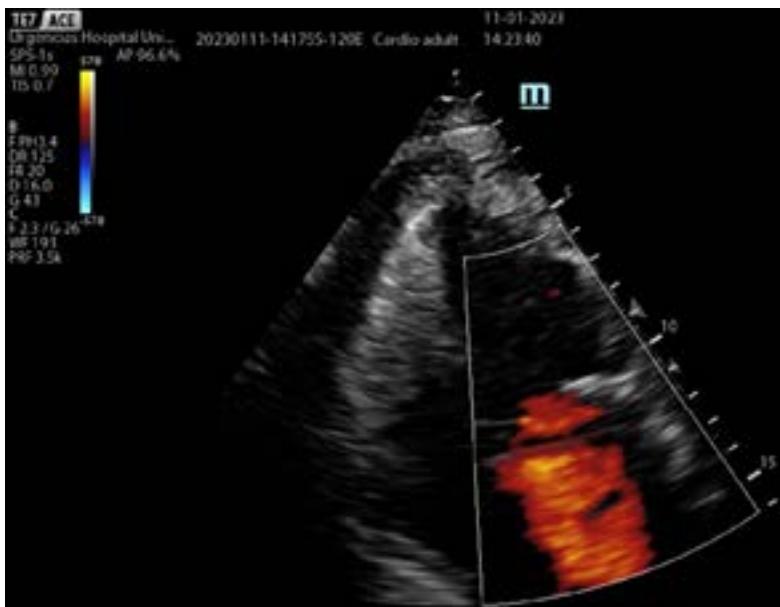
Point-of-care focused cardiac ultrasound in color Doppler mode showing periprosthetic regurgitation.
